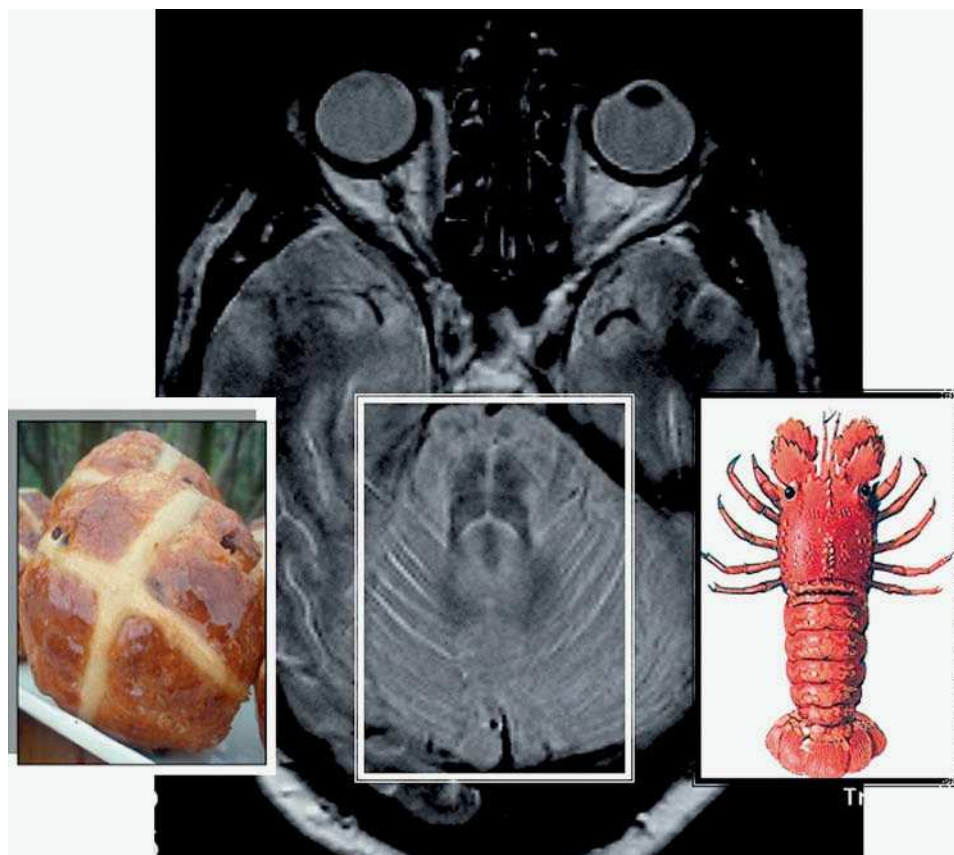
T2 axial MRI section: the pontine hypersignal resembles the hot cross bun sign (left), but when observed in association with the atrophy of the cerebellar vermis and hemisphere, it mimics the silhouette of a Santiaguíño (right).
